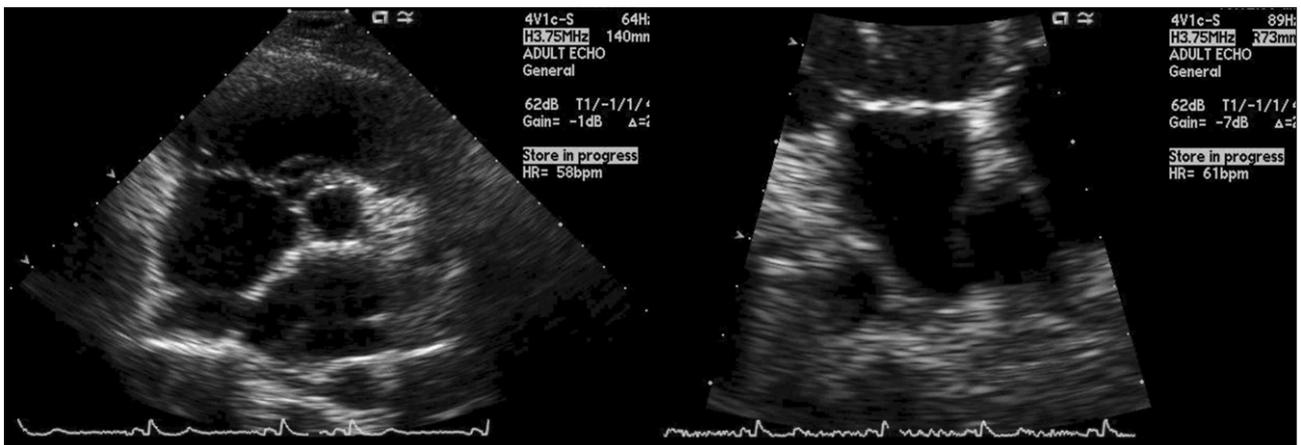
Transthoracic echocardiography showed 0.97 cm sized atrial septal defect suspected to be sinus venosus type. Left atrium looked like divided chambers by abnormal membranous structure.
